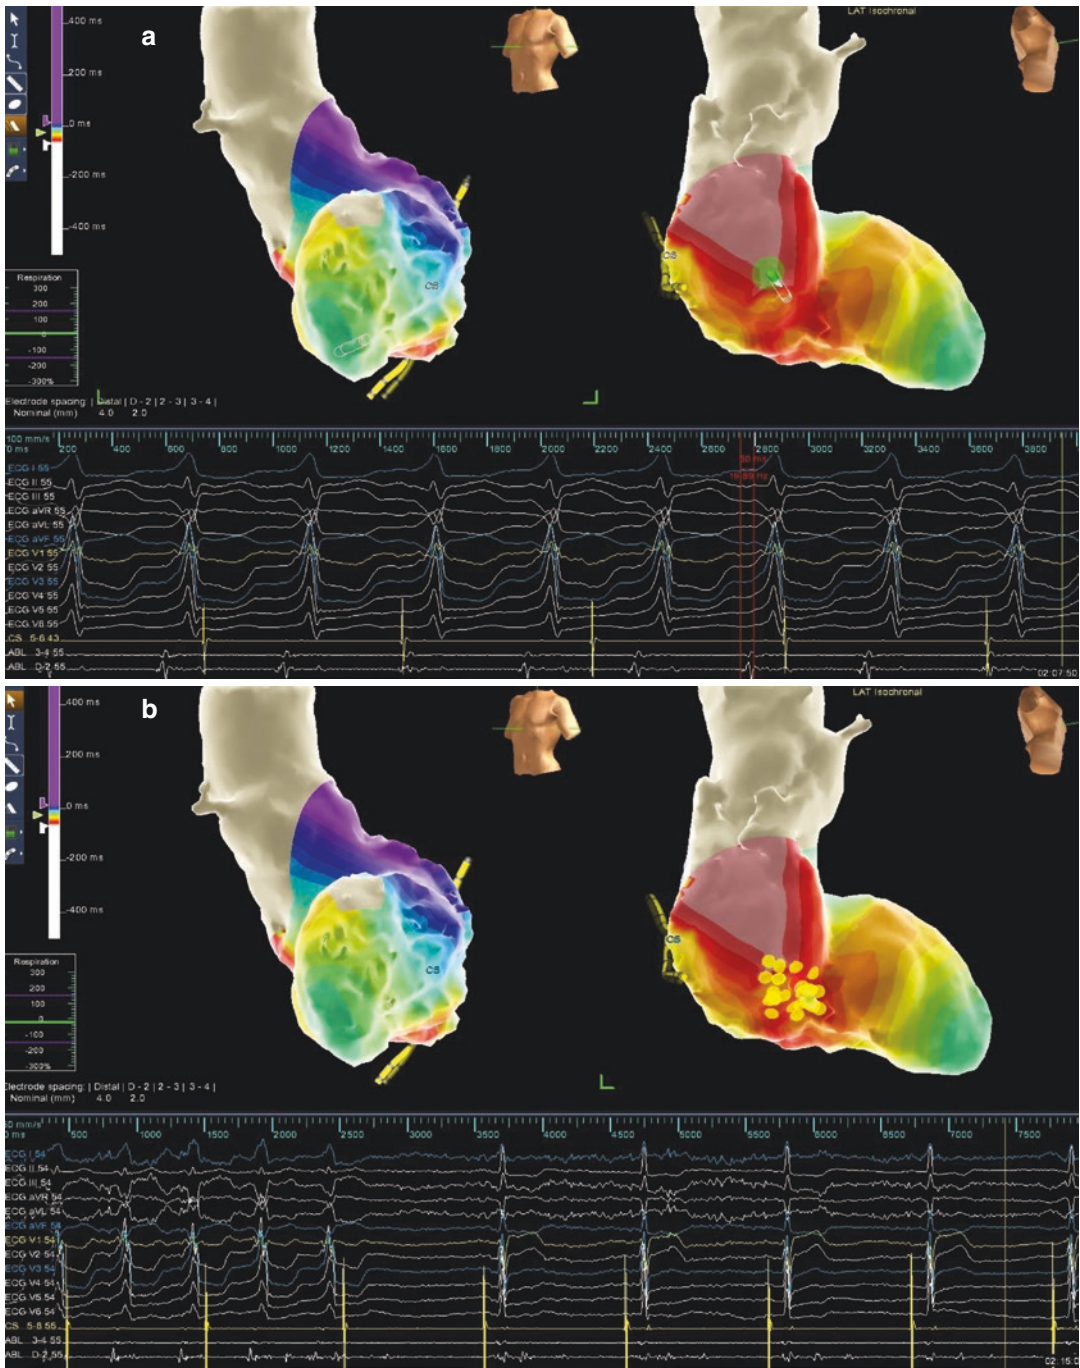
(a) Ablation under the guidance of NavX mapping immersing with CT imaging in a 54-year-old male with inferior wall myocardial infarction. (b) Ablation at
